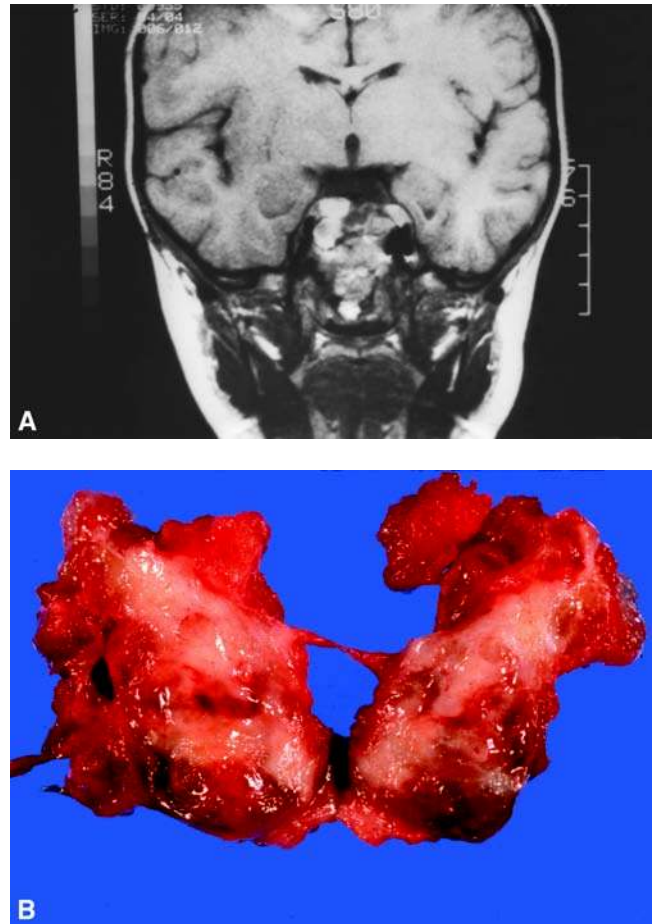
Coronal MRI demonstrating a chordoma in the base of the skull. (A) Gross resection of a chordoma. *Abbreviation:* MRI, magnetic resonance imaging.
